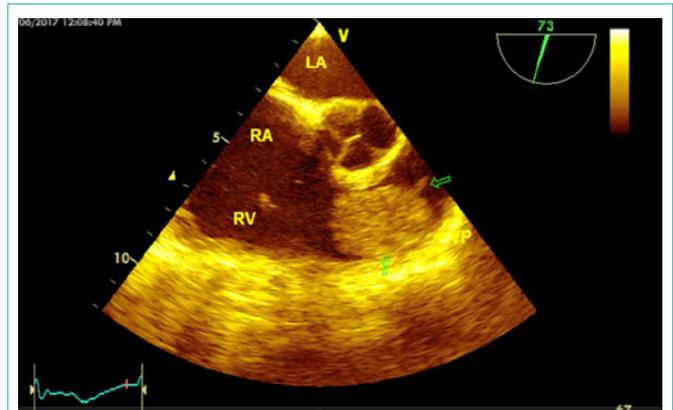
Transesophageal echocardiography study: Right ventricle and outflow views, this one not found secondary tumors. LA: Left atrium; RA: Right atrium; RV: Right ventricle; Green arrows show tumor.
